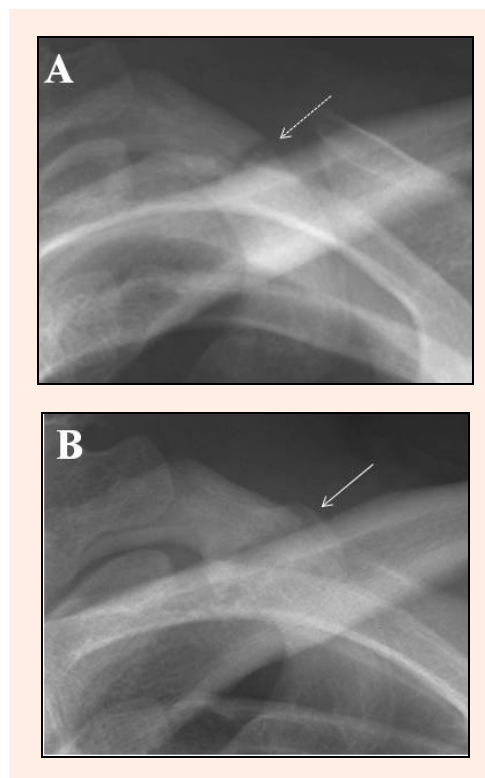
Radiographs of the first rib. Anteroposterior view at the first visit (A) and at 10 months after the onset (B). The broken arrow in (A) indicates the fracture site and the arrow in (B) indicates the bridging callus and fracture union.
